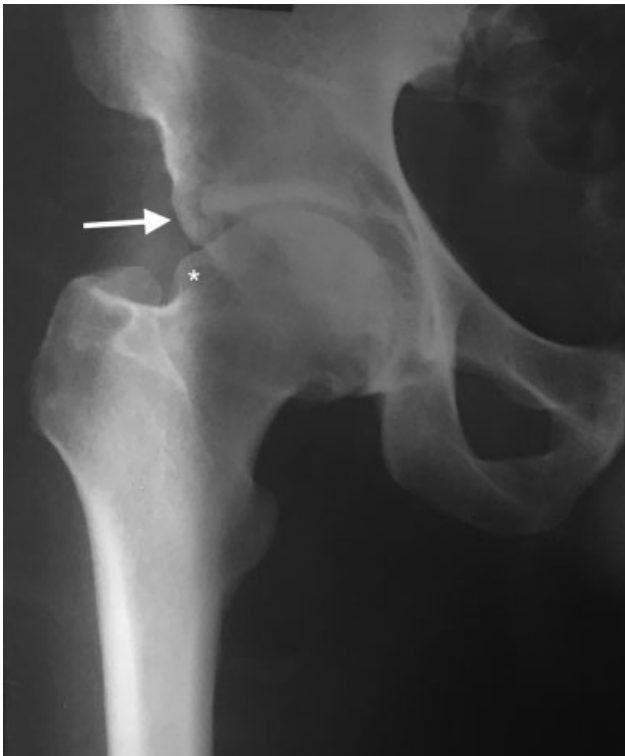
Preoperative radiography in anteroposterior view of the hip joint, showing the presence of prominent anterior inferior iliac spine (white arrow) and deformity in the neck-head transition (asterisk). center-edge Angle: 36°.
